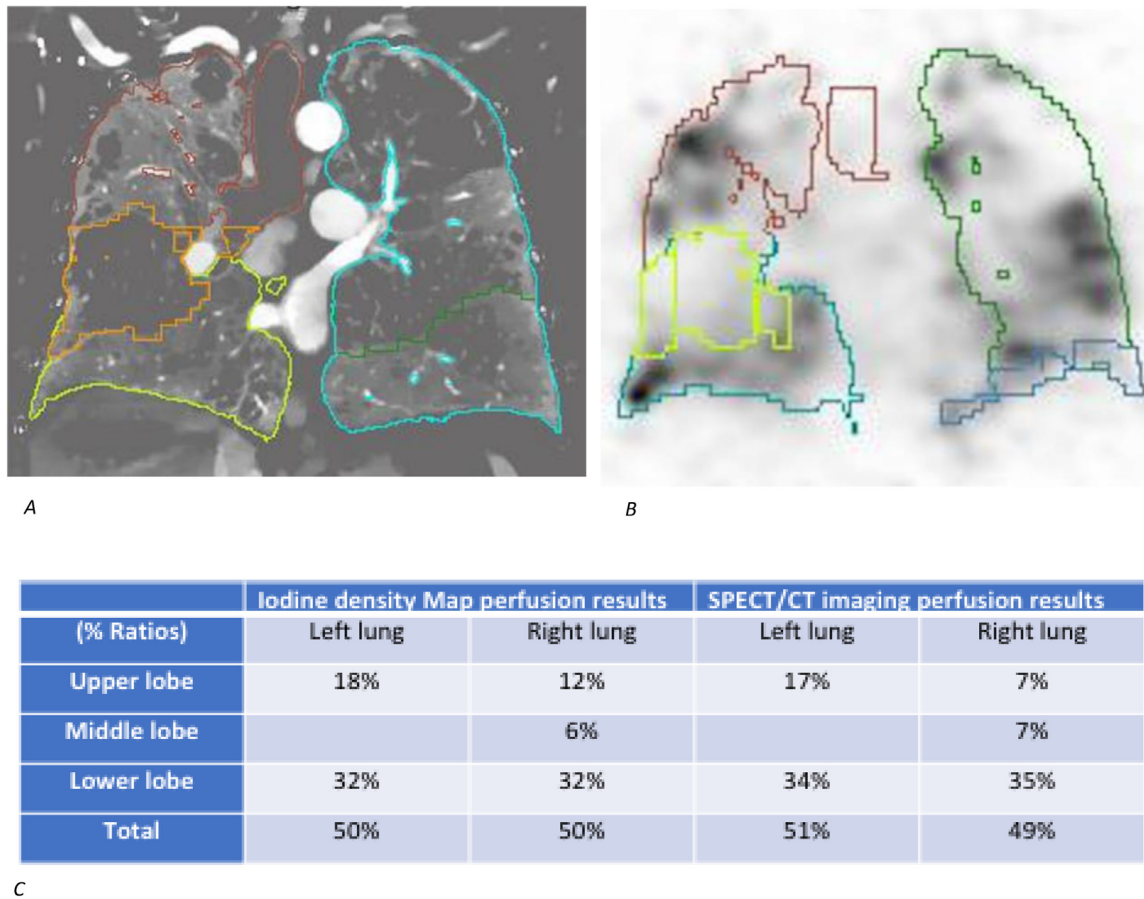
Iodine density maps (A) and SPECT images (B) show qualitatively comparable perfusion deficits in bilateral lungs, although with better inherent image resolution of iodine density map. On quantitative analysis (C), iodine maps show an almost identical lobar perfusion distribution compared to the SPECT acquisition, implying that iodine maps can be used for assessment of lung function prior to lung resection and thus obviate need for additional SPECT/CT imaging.
